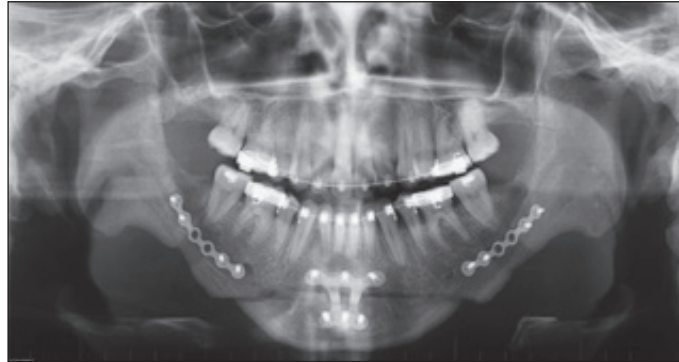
Orthopantomogram post-orthognathic surgery; April 2019.
